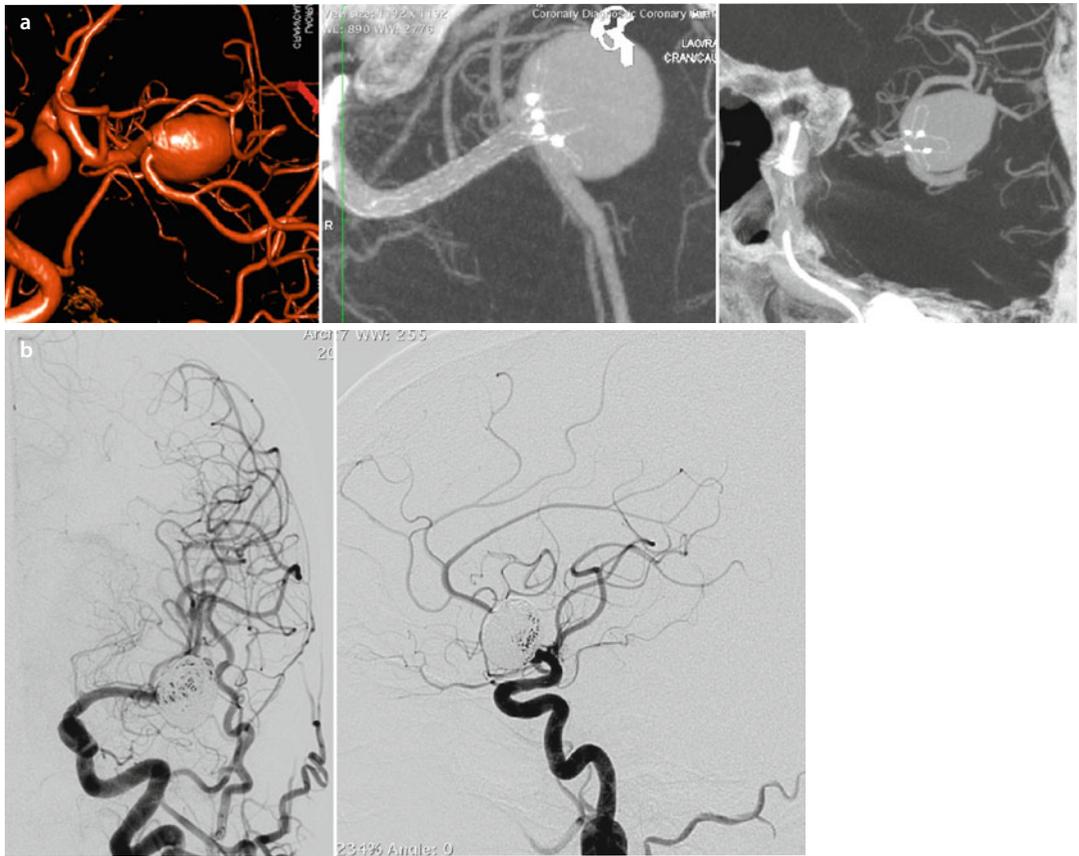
A 56-year-old right-handed woman presented in 1 December 2013 with an unruptured ACoM and left MCA GIA. (a) 3D and IAFDCTA (Dyna CTA®) reveal the MCA aneurysm incorporating both the upper and lower divisions of MCA. The initial course of the upper division is acutely angulated with a tight hairpin bend in its proximal segment. A pCONus® (Phenox GmbH, Bochum, Germany) bifurcation device was deployed to protect the origins of both the upper and lower divisions of MCA. (b) The MCA aneurysm was then coiled with a near-total occlusion. The ACoM aneurysm was also treated with Y-stenting and coiling
